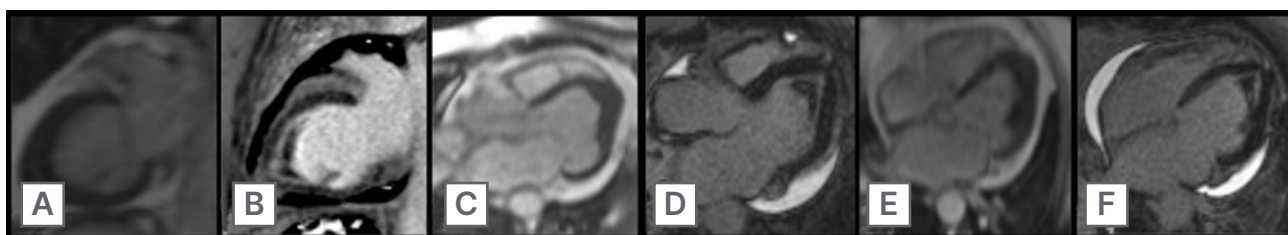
Cardiac MRI showing two chamber view of late gadolinium enhancement (A-C), and four chamber view of late gadolinium enhancement and left ventricular thrombus (D-F).
